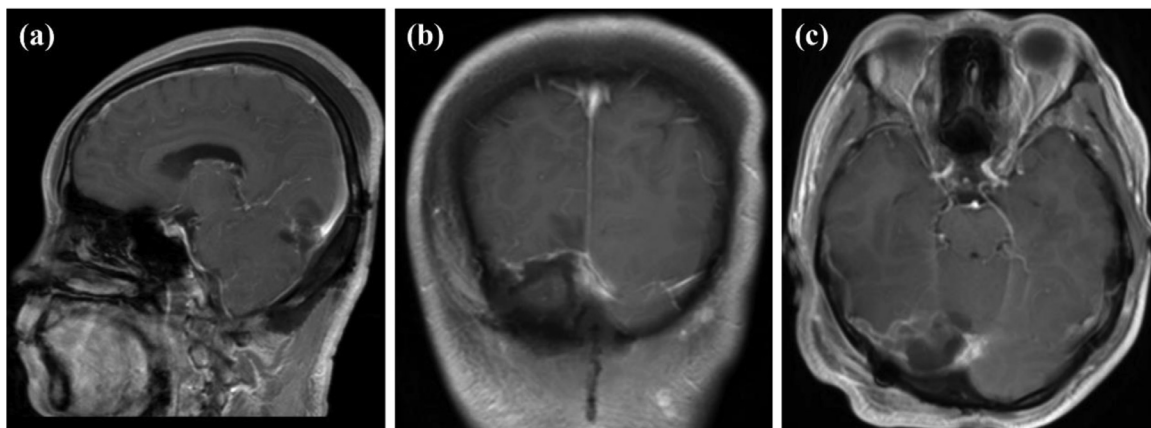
Postoperative MRI revealed no residual tumor (a-c).
